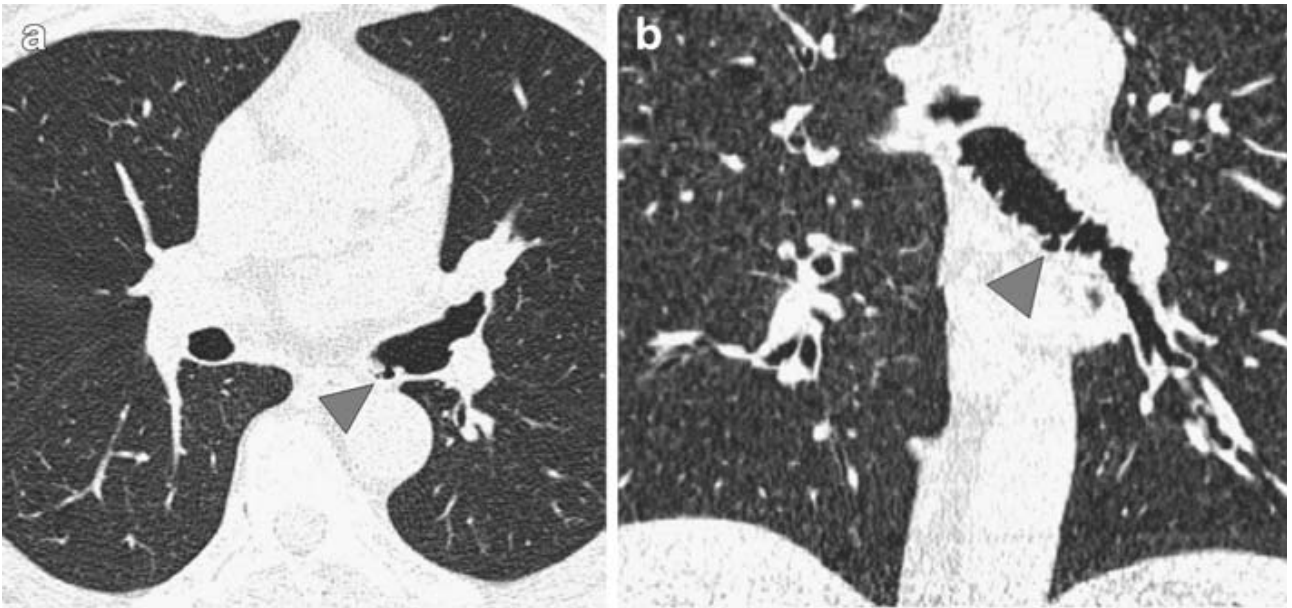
Discordant evaluations in a case of a 69-year-old female smoker. Thin-section CT axial (a) and coronal (b) images clearly depict an air space communicating with the left main bronchial lumen (arrowhead), consistent with a bronchial diverticulum. However, the coronal image also shows a corrugated contour of the bronchial wall that was interpreted as grade 2 bronchial diverticula by one radiologist, but as grade 1 bronchial diverticula by the other.
